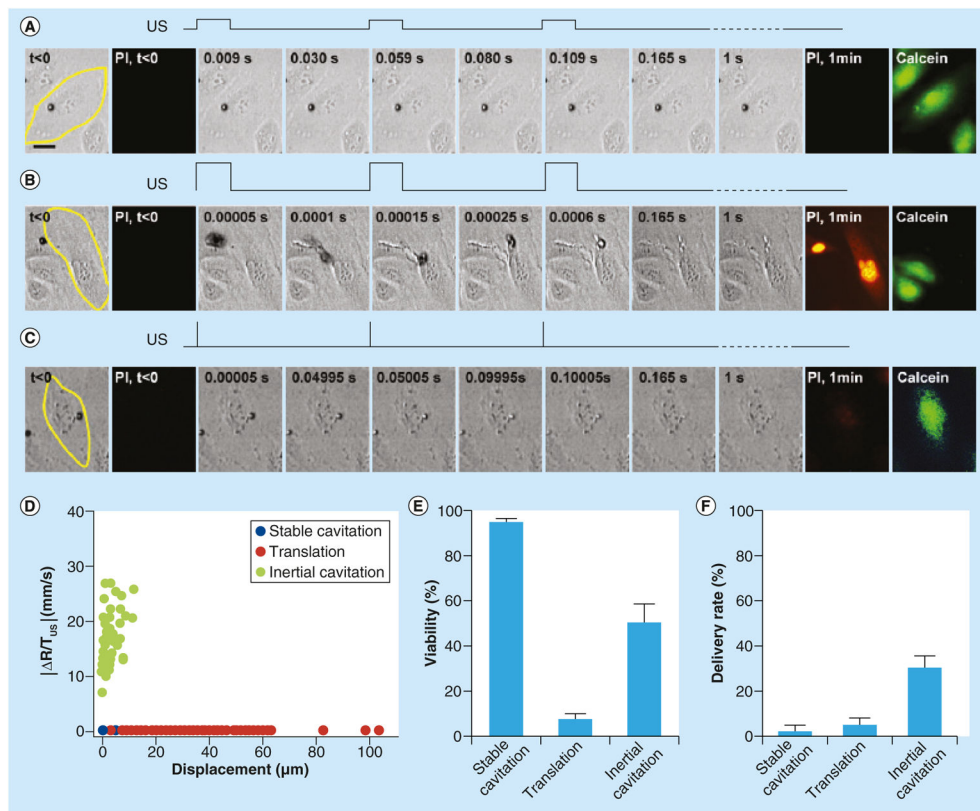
Three typical types of bubble dynamics in application circumstances driven by different ultrasound conditions
